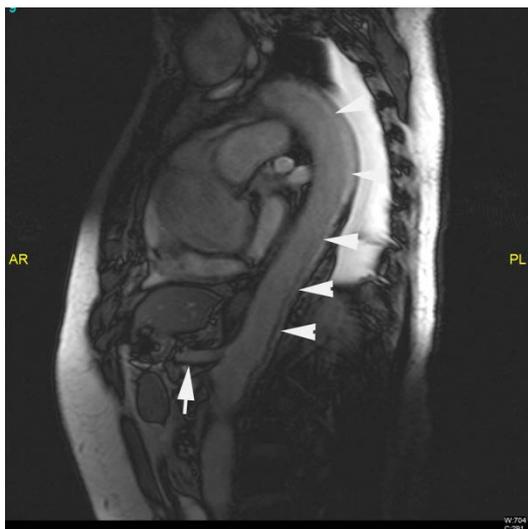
Sagittal MRI chest showing intact celiac trunk (white arrow); and dissection extending to descending aorta (white arrow head)
